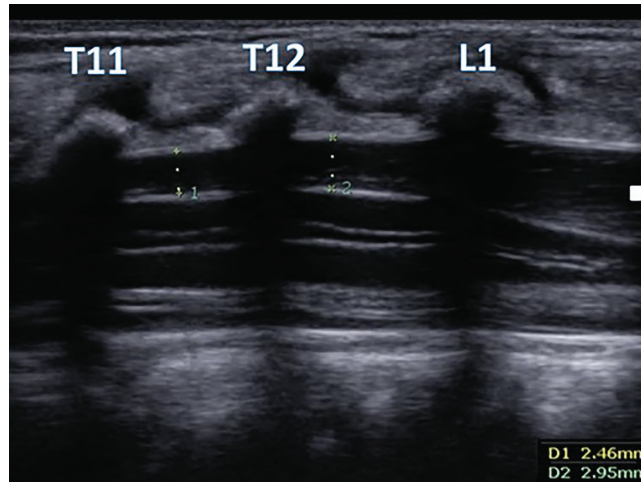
An ultrasound image shows the maximum distance of the spinal cord from the posterior wall of the canal between T12 and L1(2.95 mm) in a healthy infant.
